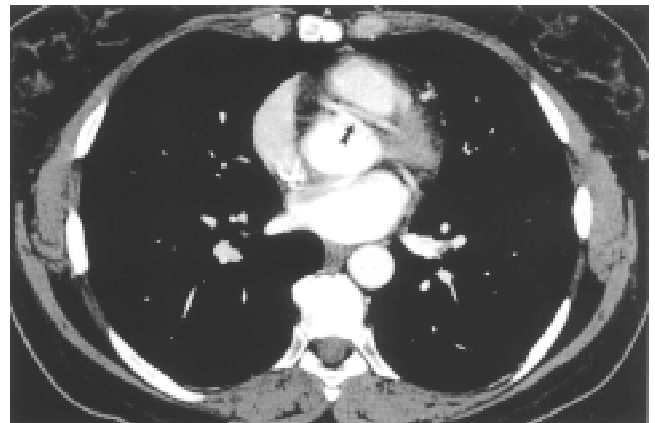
Spiral computed tomography shows anomalous origin of LMCA with interarterial course. The arrow indicates the left main coronary artery taking a path between the ascending aorta and pulmonary trunk.
